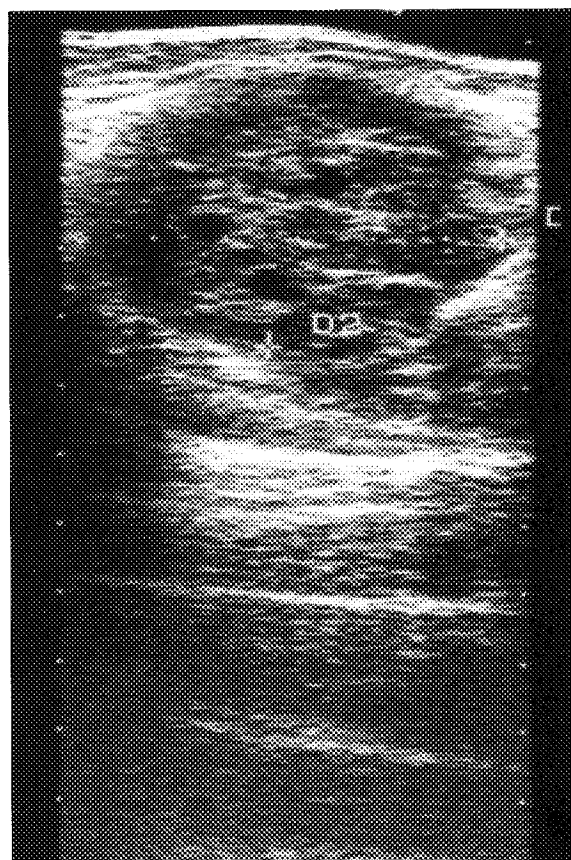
Ultrasonography of the left thigh. Sharply-demarcated hypo-echoic mass containing several centrally-located fluid-filled cavities.
